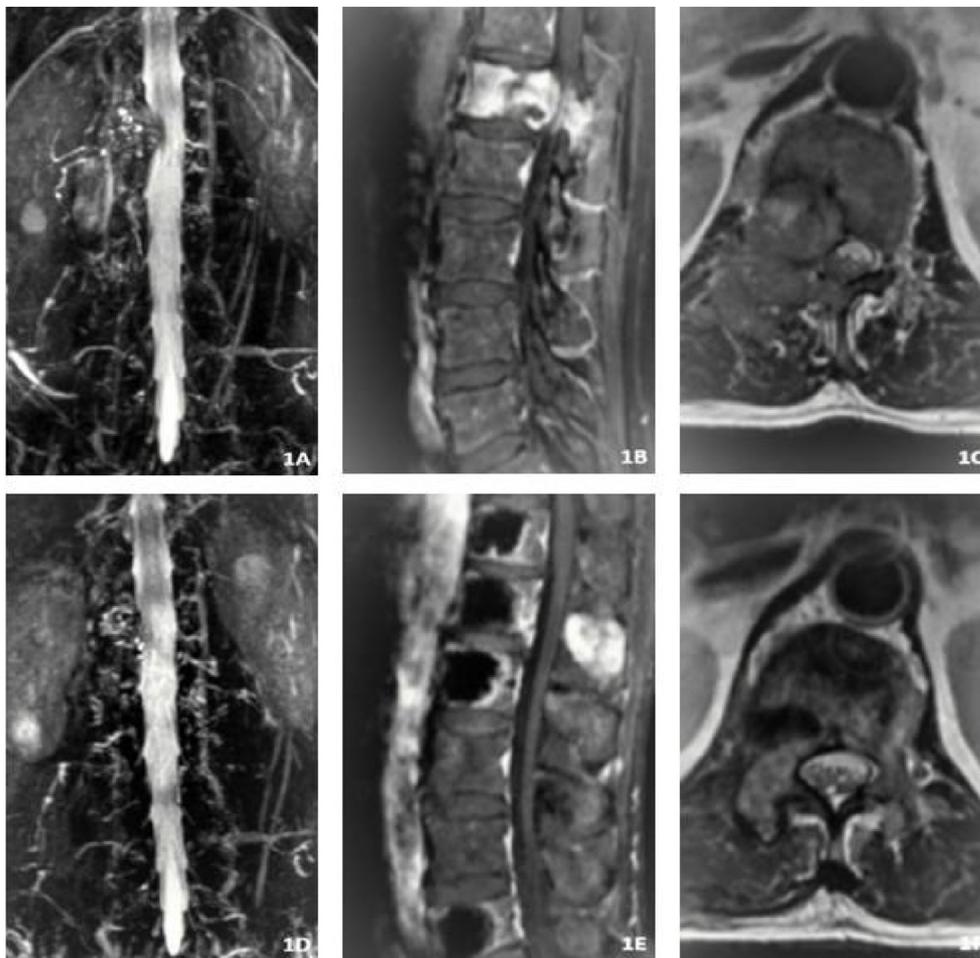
Imaging data for bone metastasis of thyroid cancer treated with PVP and RFA. (1A), (1B), and (1C) MIP images of preoperative lumbar MRI, sagittal T1WI, and transverse T2WI showing abnormal signals of the L1 vertebral body and right adnexa, accompanied by the formation of soft tissue at the right posterior margin of the vertebral body and the corresponding spinal stenosis; (1D), (1E), and (1F) images obtained 3 months after the operation, respectively. Reexamination of MIP images with enhanced lumbar MRI, sagittal T1WI, and transverse T2WI scans showed that the metastasis was significantly smaller than that before the operation, and the compression of the spinal cord was significantly reduced.
